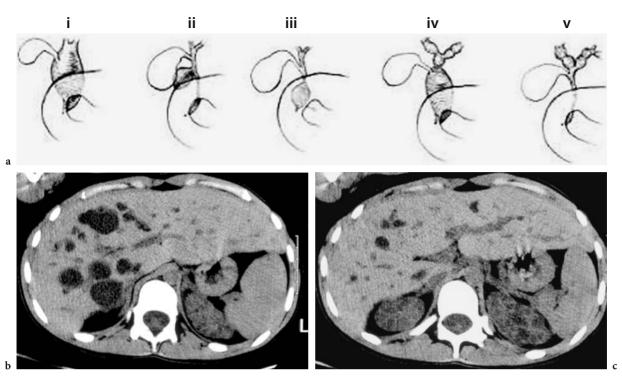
a Classification of choledochal cysts. b,c CT demonstrates multiple cystic dilatation (saccular), signifying Caroli's "disease"
